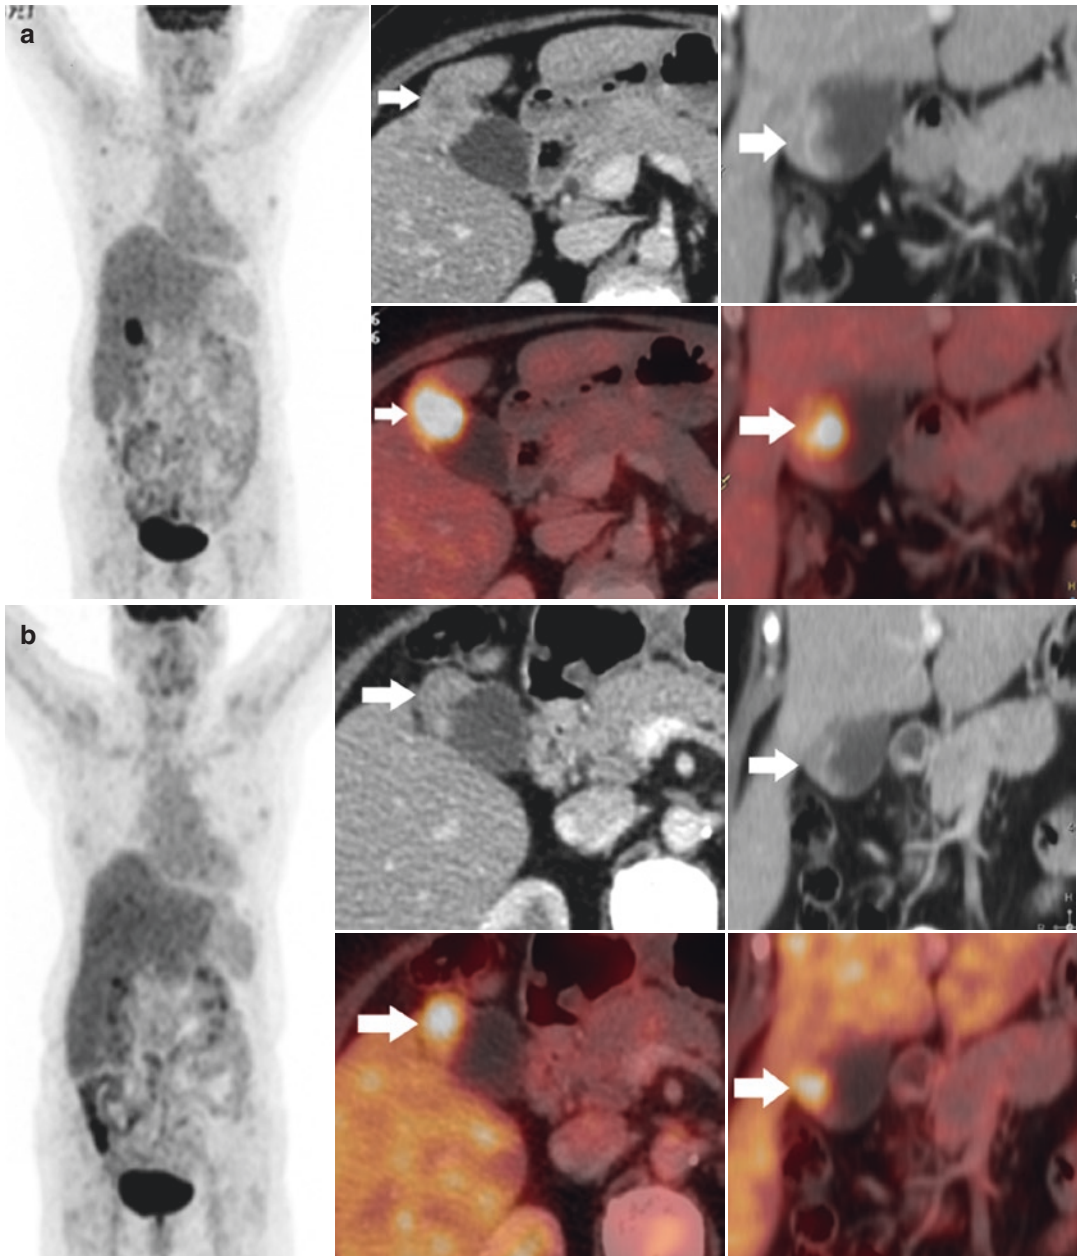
Complete metabolic response: Staging  $^{18}\text{F}$ -FDG PET/CT (a) shows intensely FDG avid soft-tissue mass involving the gall bladder (arrow). The mass is infiltrating the adjacent liver parenchyma (SUVmax 16.0). (b)
